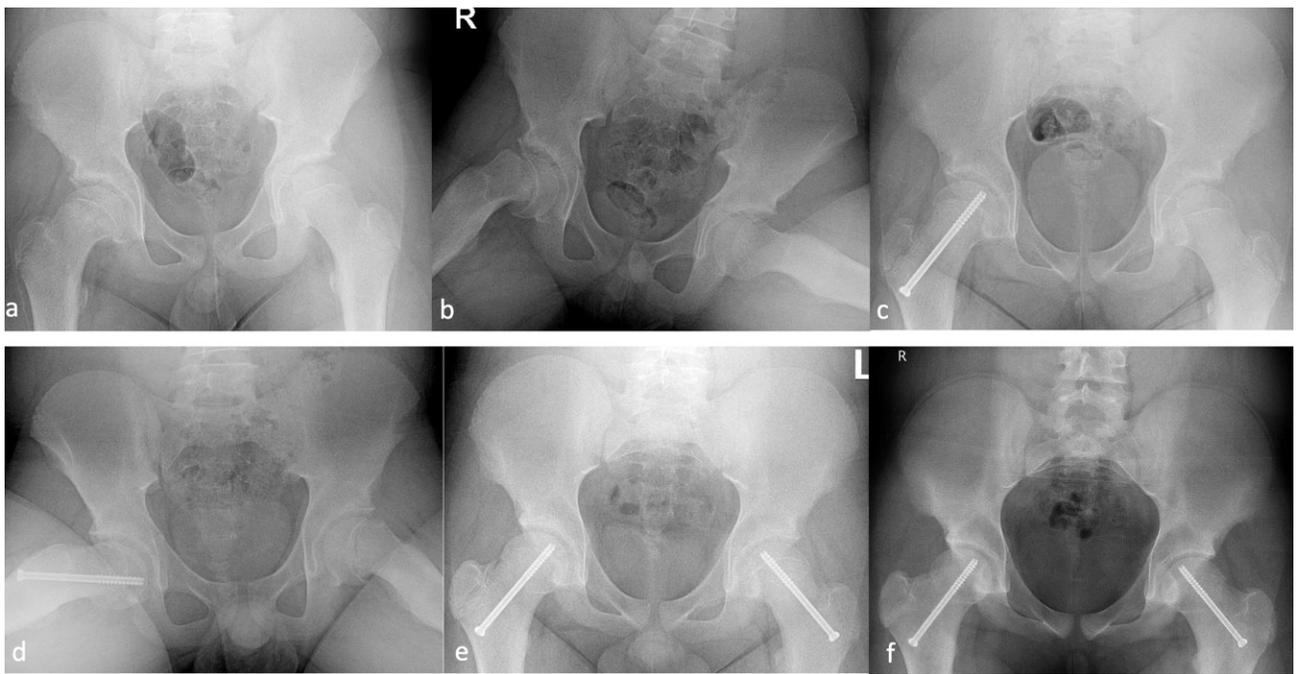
A 13-year-old-boy with SCFE on the right side (a-c) treated with in situ pinning (c). 17 months after the initial surgery, the patient was diagnosed with subsequent SCFE of the contralateral hip, which was treated with in situ pinning of the left side (d and e). Final radiograph at age 16 (f).
